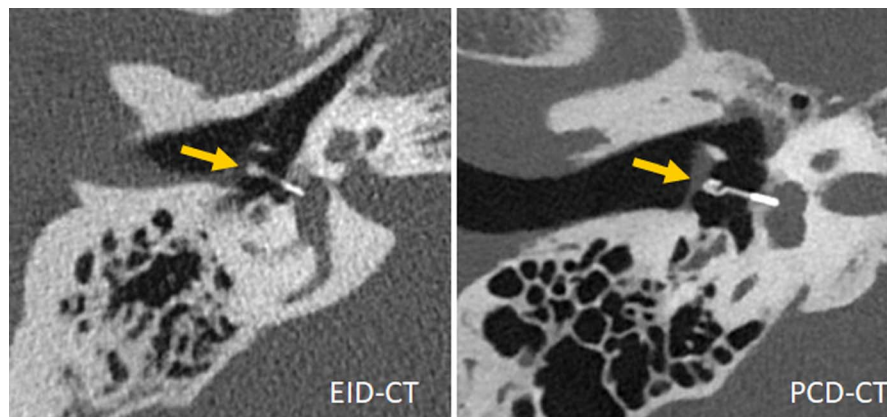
Inner ear scans acquired with a third-generation DSCT (left) and a first-generation PCD-DSCT, (right), demonstrating superior visualization of a Titanium K-piston stapes prosthesis (arrow, distal end diameter 0.4 mm) with PCD-CT. Courtesy of Dr A. van der Lugt, Erasmus Medical Center, Rotterdam, the Netherlands.
